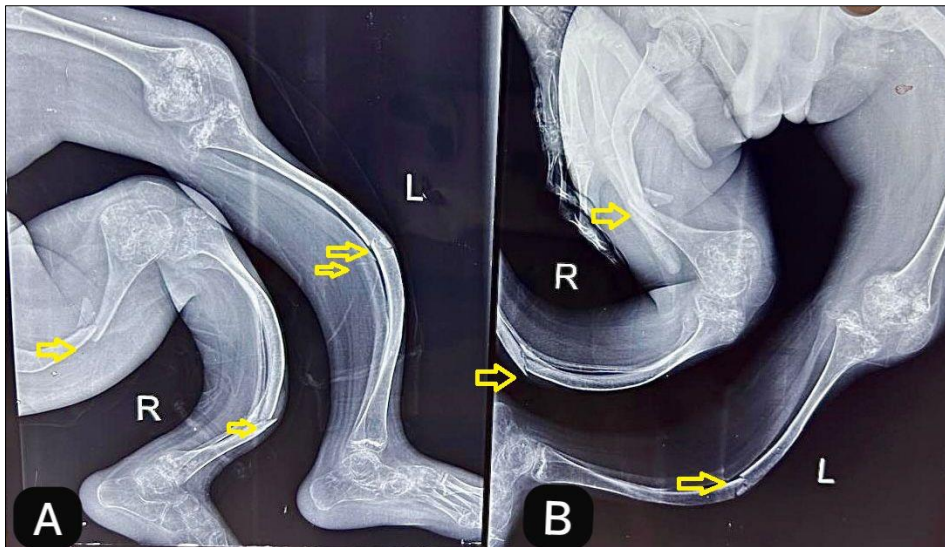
Plain radiographs of bilateral lower limbs demonstrating severe skeletal deformities
